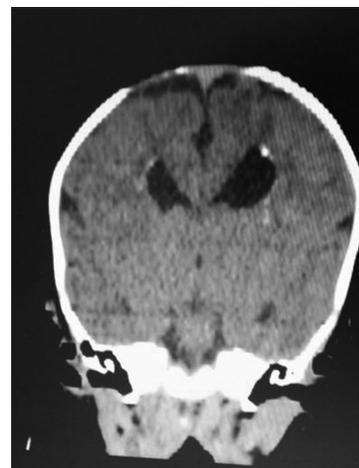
Computed tomography scan showing bone defect at both parietal and parasagittal bones
